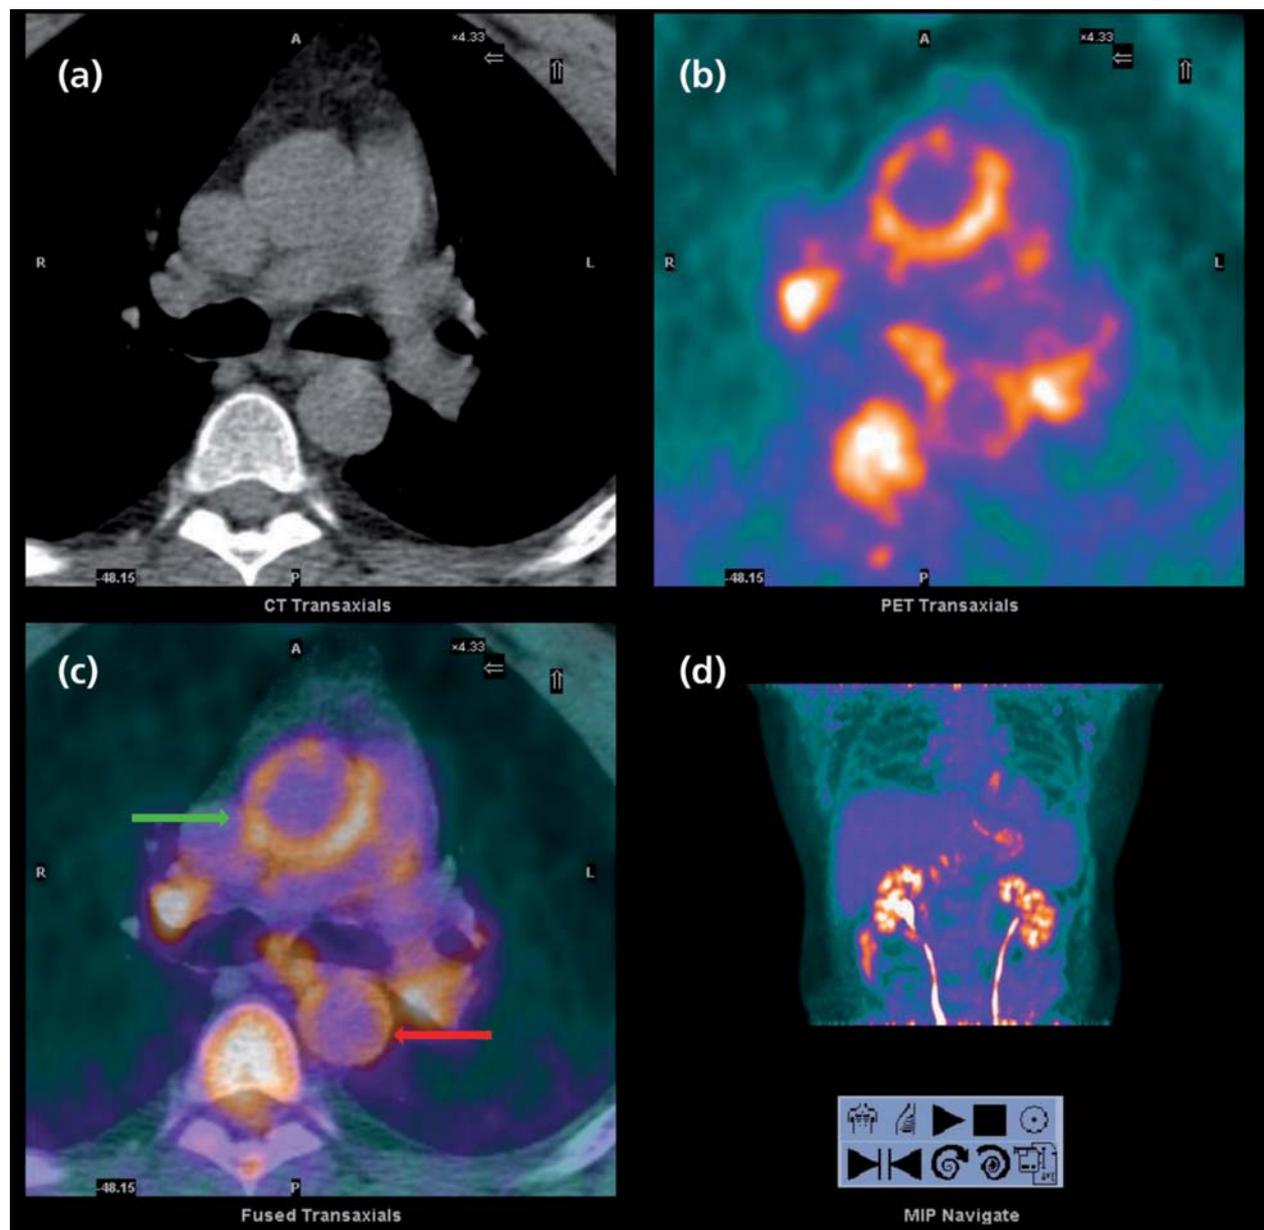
Imaging vascular inflammation with FDG-PET/CT. (a) Transaxial CT image of the ascending aorta at the level of the main pulmonary artery. (b) Corresponding transaxial FDG-PET image at the same location. (c) Fused PET/CT image allowing for anatomical co-localization of FDG uptake. Circumferential uptake is noted in both the ascending aorta (green arrow) and the descending aorta (red arrow). (d) Coronal FDG-PET image in the same patient. There is relatively little myocardial uptake in this case, while renal excretion of the tracer is noted. CT, computed tomography; FDG, [18F]-2-fluoro-2-deoxyglucose; PET, positron emission tomography.
